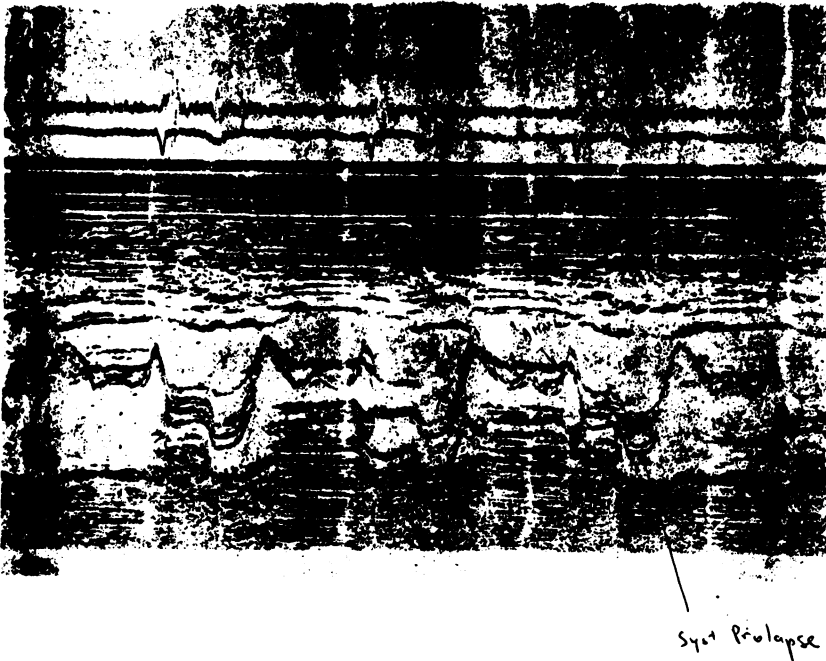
Echocardiogram demonstrating prolapse of the posterior leaflet of the mitral valve
